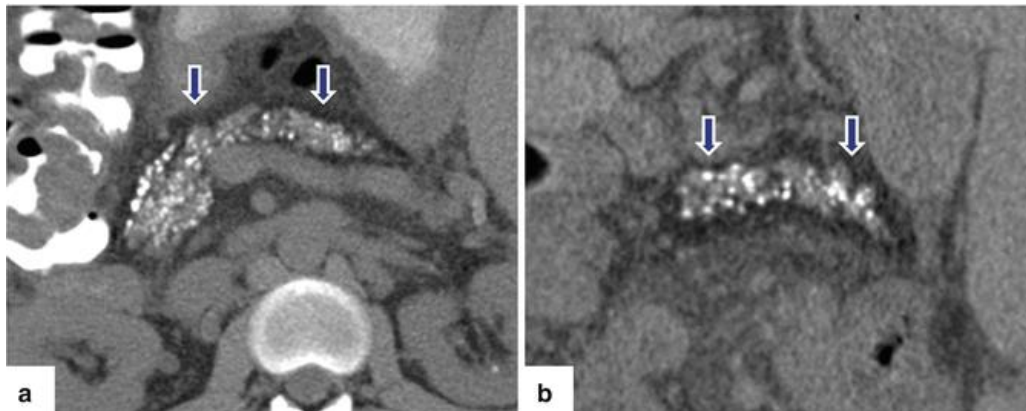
Chronic pancreatitis on CT: A 37-year-old male with history of cystic fibrosis. Non-contrast CT axial images (a, b) reveal multiple, small pancreatic calcifications and parenchyma atrophy with diffuse fatty infiltration (arrows) of the pancreatic parenchyma [31]
